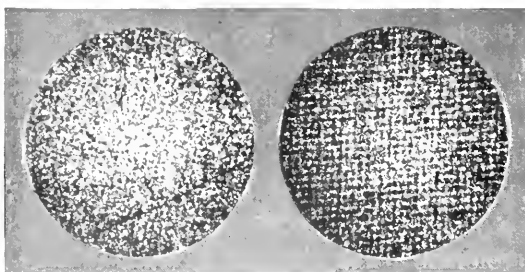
SHOWING GRAININESS OF X-RAY INTENSIFYING SCREENS; MAGNIFICATION, 9 DIAMETERS.
